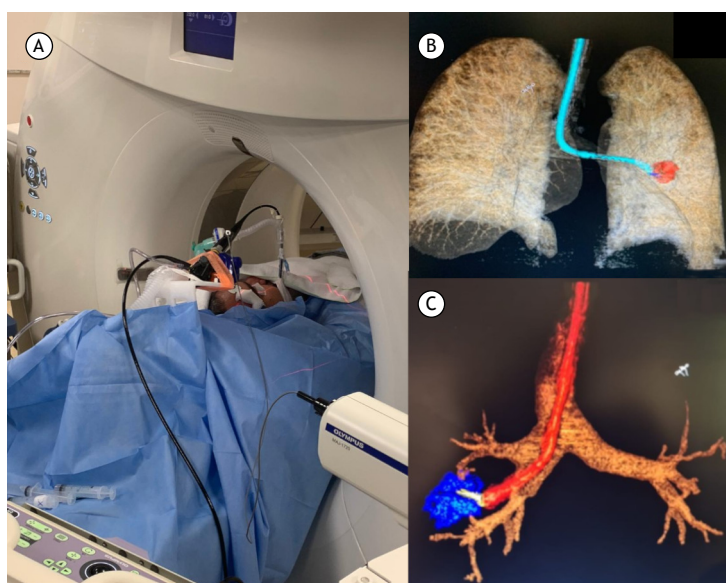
Combination of bronchoscopy techniques using radial EBUS and CT for the diagnosis of a pulmonary nodule. In A, patient in the procedure room, undergoing simultaneous bronchoscopy with radial EBUS and CT. In B and C, three-dimensional CT reconstruction to guide the biopsy procedure.
